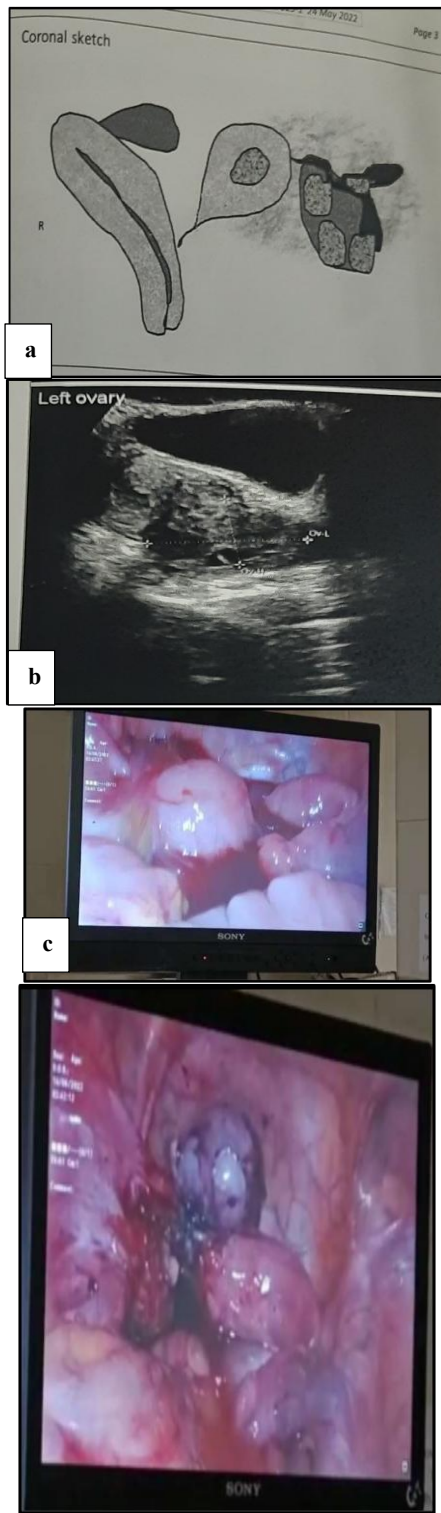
(a) coronal sketch depicting the uterine duplication anomaly with a non-communicating rudimentary left horn; (b) left adnexa on ultrasound showing endometriotic cysts; (c) laparoscopic view of the bulky non-communicating rudimentary left horn with left tubo-ovarian endometriotic cysts; (d) laparoscopic view during resection of the left horn with ovarian cystectomy.
